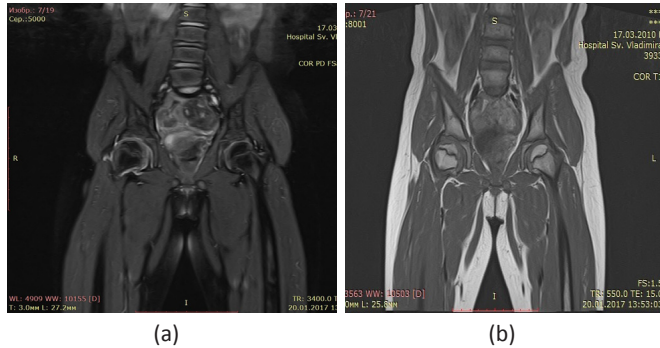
MRI, PD Fat Sat (a), T1 (b), frontal view: LCPD, right side, stage I.
